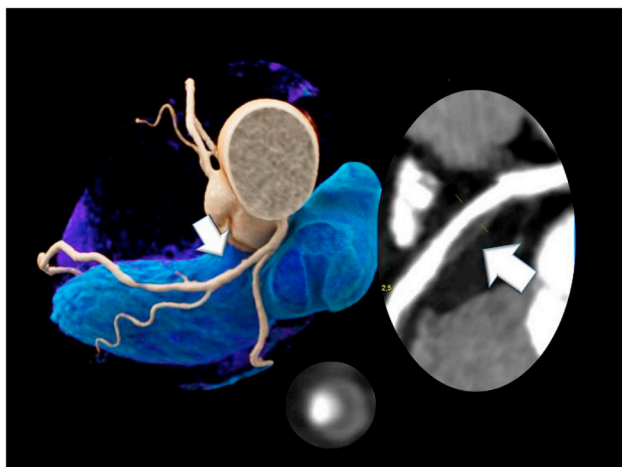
Curved multiplanar reformation of a 67 year-old-man, inactive, BMI of 27, 2 risk factors, atypical chest pain, CAC score 0, segment involvement score 2, and G-score 8. CCTA (right inset): Non-calcified plaque in the proximal LAD with 3 high-risk criteria (low-attenuation fibrofatty plaque with lipid-necrotic core plaque (4 HU), napkin-ring sign (lower inset), and positive remodeling with a RI 1.5). BMI, body mass index; CAC, coronary artery calcium; CCTA, coronary computed tomography angiography; HRP, high-risk plaque; HU, Hounsfield units; LAD, left anterior descending; RI, remodeling index.¹³
